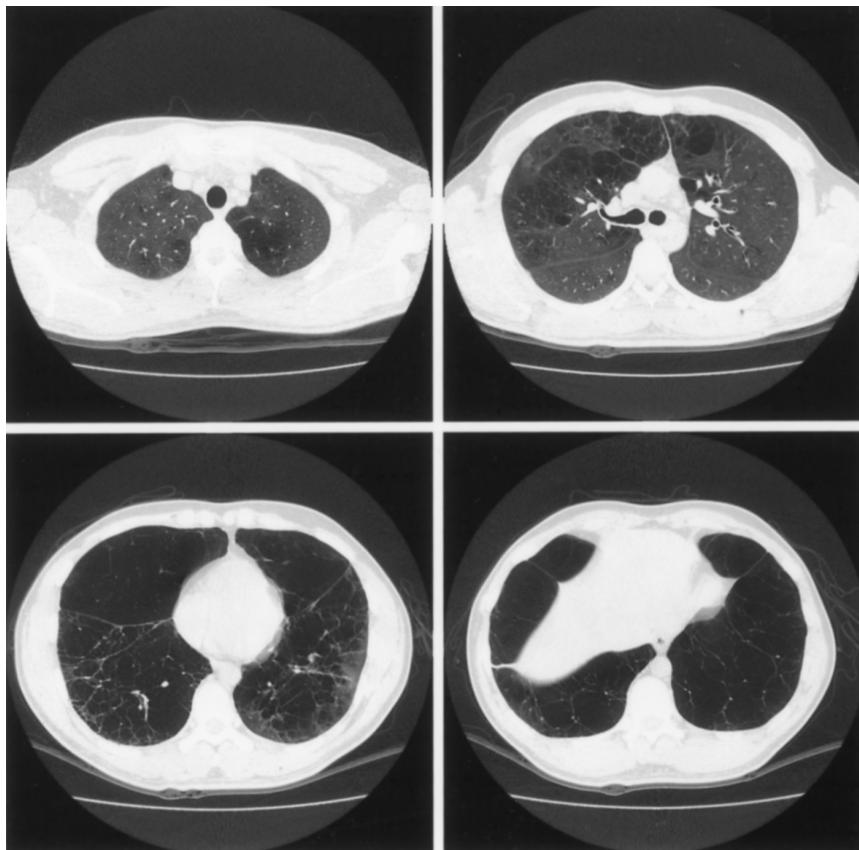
High resolution computed tomography demonstrated panlobular emphysema with a lower lobe preponderance.
